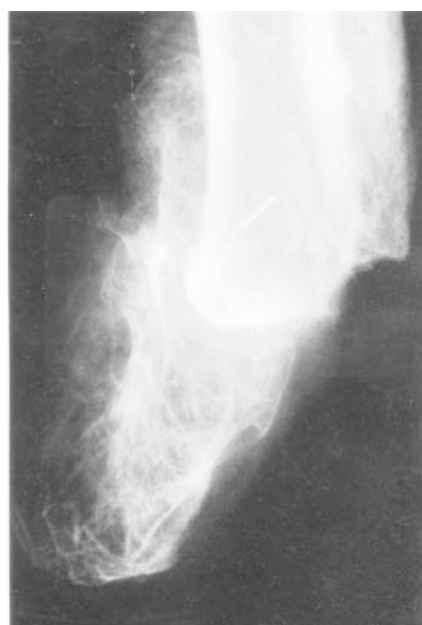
Radiograph of the right foot of patient no.2 demonstrating extensive lytic destruction of the tarsal bones and involvement of the distal epiphyses of tibia and fibula.
